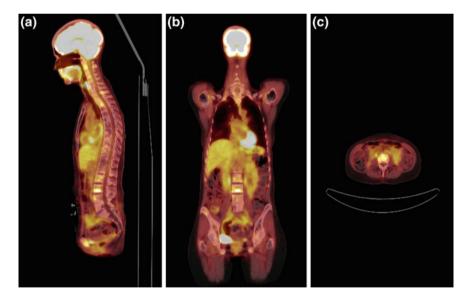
PET/CT images obtained extending from the head to the mid-thighs. Fused CT and PET images in a sagittal, b coronal, and c axial projections. Areas of *light yellow* to *orange* again represent areas of increased radiotracer uptake, and areas of red, lower uptake. Note that there is a normal increased and expected physiologic uptake of radiotracer, in the brain and heart, with increased activity also noted in the liver, kidneys. This case, however, also demonstrates foci of abnormally increased radiotracer uptake in the spine, diagnosed as metastatic disease to bone. (compare Fig. 19)
